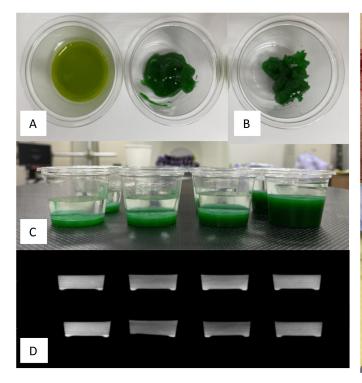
Carboxymethyl cellulose (CMC) 1 g with a green dye and saturated zinc chloride water (2 ml) were added into a cup and mixed immediately. A: The liquid was light green (modified Mohs paste based on CMC [moM-CMC] liquid, the left image). One milliliter of purified water was then added to the liquid with stirring (moM-CMC sol, the right image). The moM-CMC liquid or sol was transferred to a new cup. B: After an hour, the moM-CMC sol transitioned to a gel. C: 10 ml of saline solution was poured into the moM-CMC sol of different thicknesses (front: 1.6, 4.1, 5.7, and 14.7 mm from left, behind: 3.7, 4.5, 7.3, 13.4 mm from left). D: The saline solution was removed, measured, and subjected to computed tomography (window level 200 Hounsfield unit [HU] and window width 200 HU).
